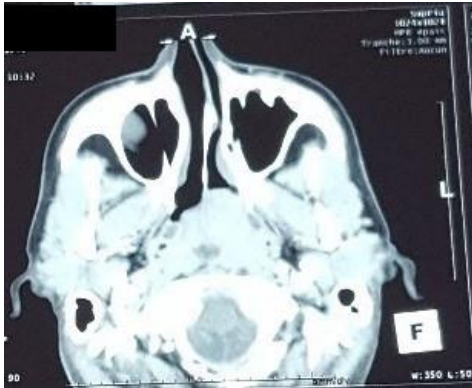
CT-scan in axial plane showing a tumoral mass of the left side of the posterior wall of the nasopharynx.
